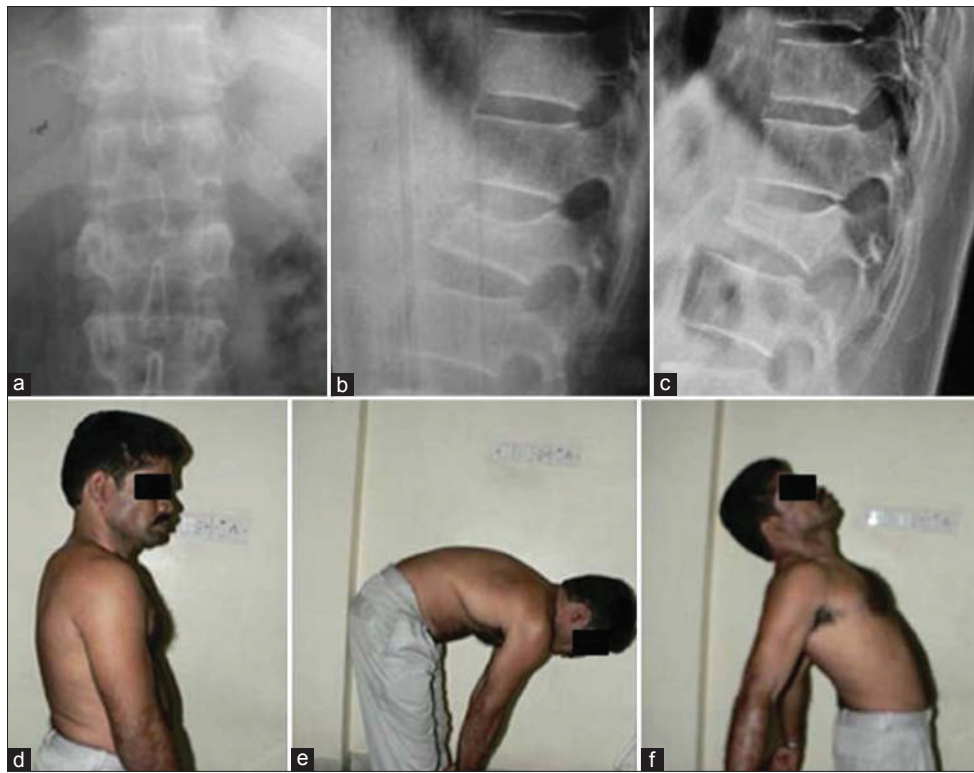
Stable burst fracture of L2 vertebral body treated by conservative care. Lateral radiograph at the end of 1-year shows good fracture healing. Clinical pictures show good functional outcome
